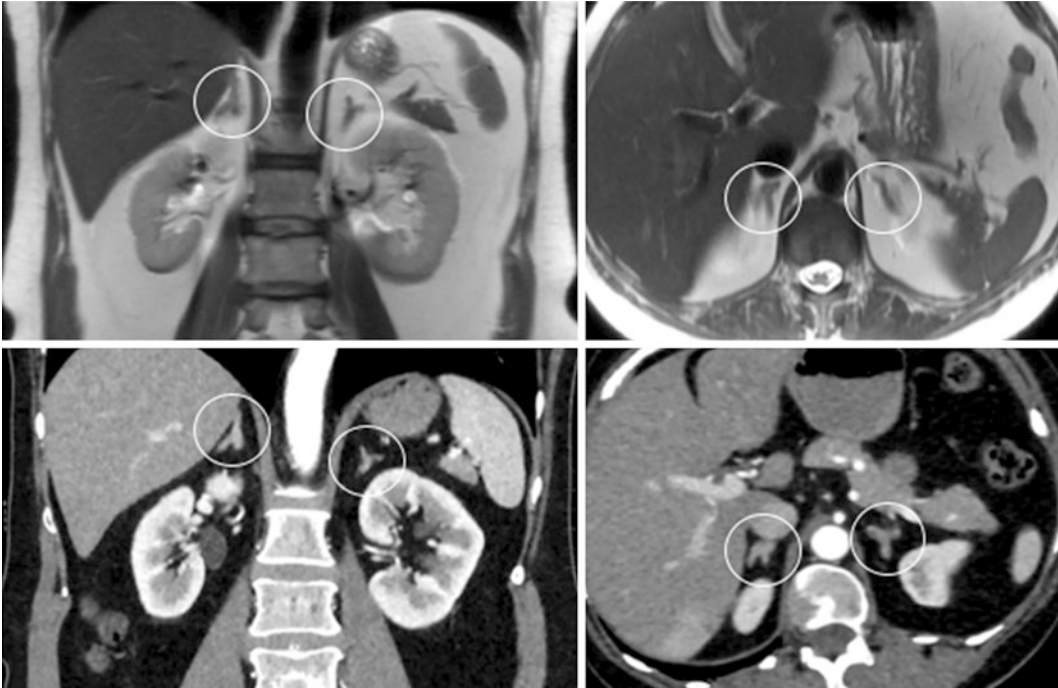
Normal adrenal glands. Triangular adrenal glands in a healthy individual on CT (above) and MR (below) images
